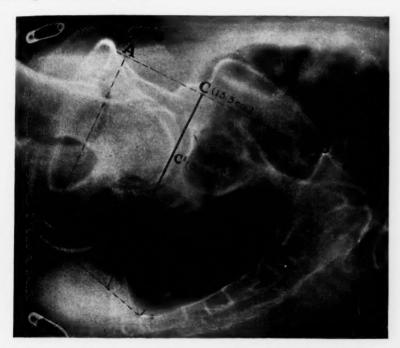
Roentgenogram of the pelvis of a primipara. Note that the pelvic depth (line C) is considerably greater than the pelvic depth in Fig. 1. Note also the increased depth from the forepelvis to the posterior pelvis. Fourteen months before this study was made the patient delivered a child weighing seven pounds after a sixteenhour labor.
